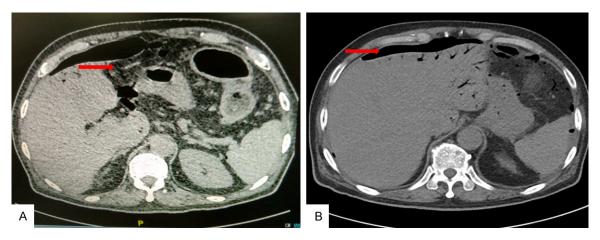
A, B. Abdominal CT showed a large amount of free gas in the abdominal cavity. A. The narrow of bowel cavity was caused by tumor and the expansion in the upper bowel.
